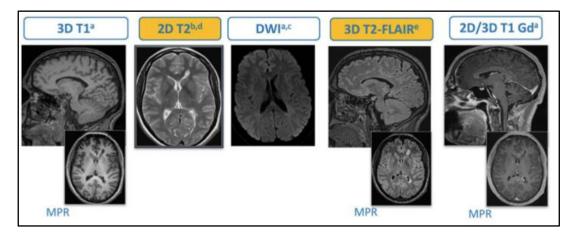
MRI: Basic protocol of brain MRI in the diagnosis and follow-up of MS.
